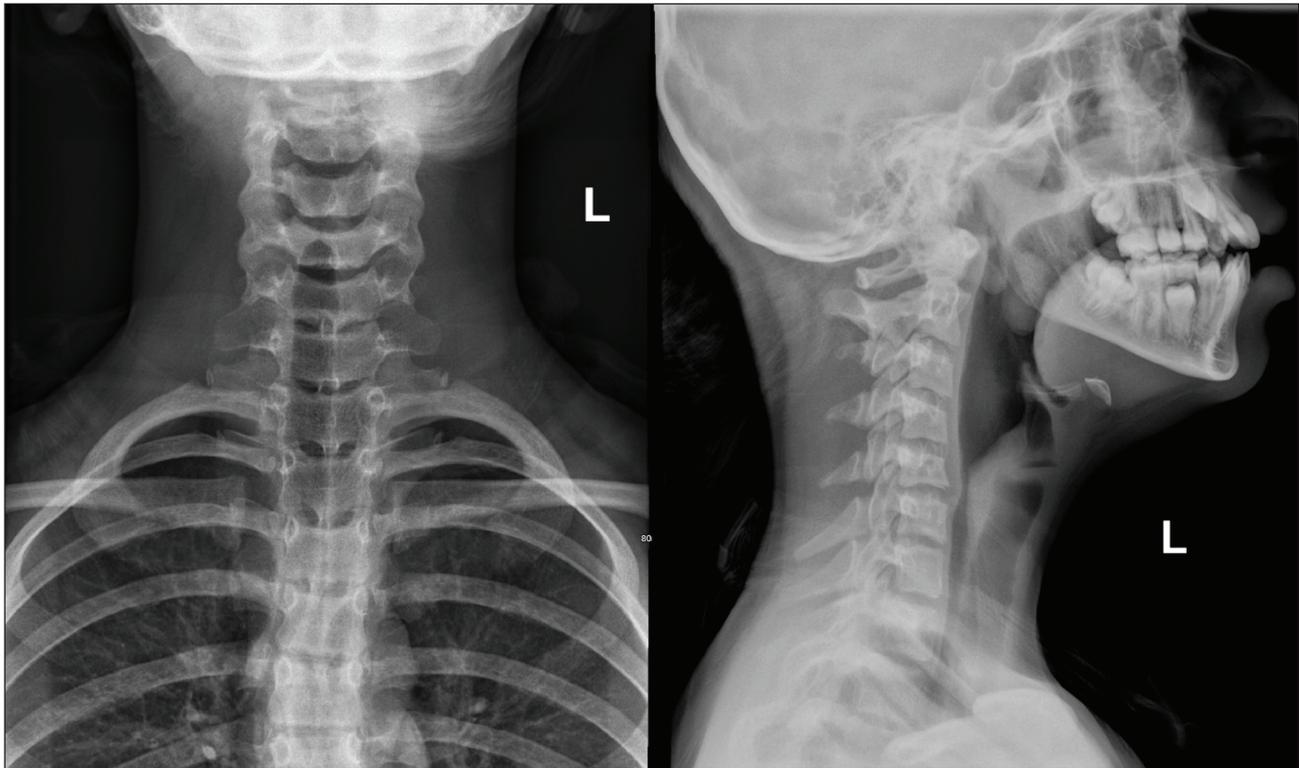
Neck soft-tissue radiograph from the second visit showing the “steep sign” on the PA view, indicating subglottic narrowing consistent with croup.
